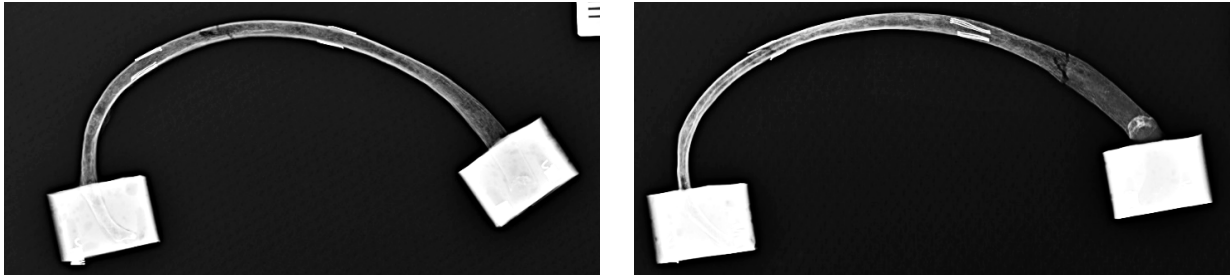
Pair 5 rib (left) and rib+CC (right) post-test x-rays (not to scale)
